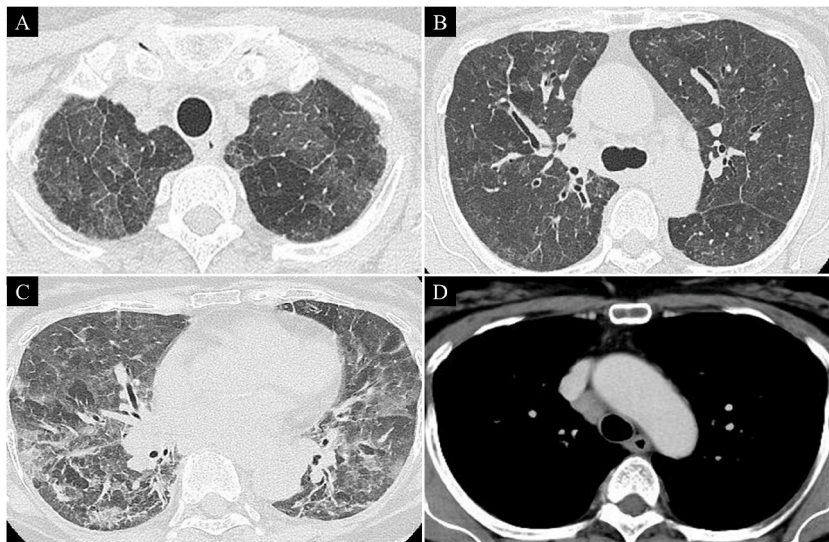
HRCT on admission
